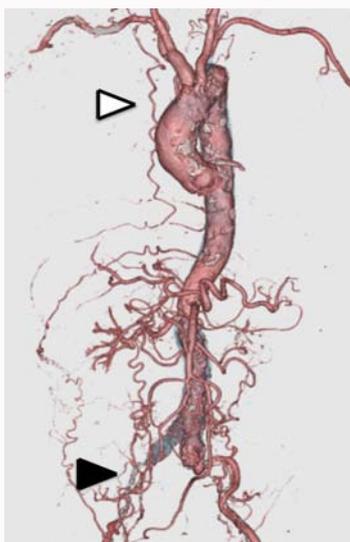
Preoperative computed tomography scan showing occlusion of the right common iliac artery (black arrowhead) and dilatation of the right internal mammary artery, which supplied the collateral flow to the right femoral artery (white arrowhead).
